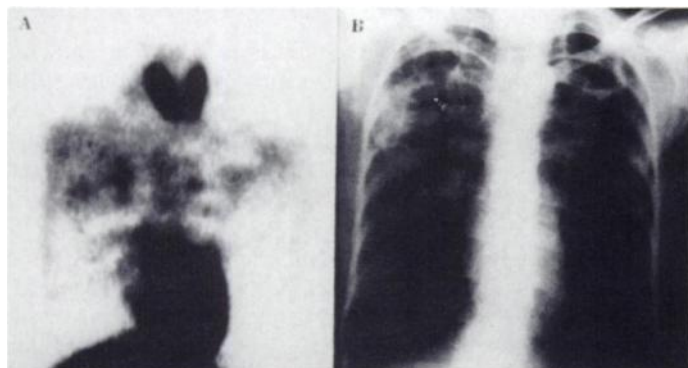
(A) Technetium-99m-tetrofosmin scintigraphy and (B) planar chest radiograph of patient with APTB (Patient 23). Cavitory disease together with fibronodular infiltrations in left upper and middle zones and in right upper and middle zones are seen on chest radiograph. There is marked ^{99m}Tc-tetrofosmin uptake surrounding cavity and at infiltrative area.
